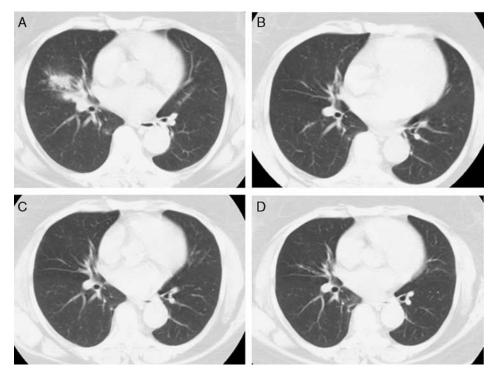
Chest computed tomography showing (A) right perihiliar infiltrate. Resolution of infiltrates (B) 3 months, (C) 9 months, and (D) 21 months later.
